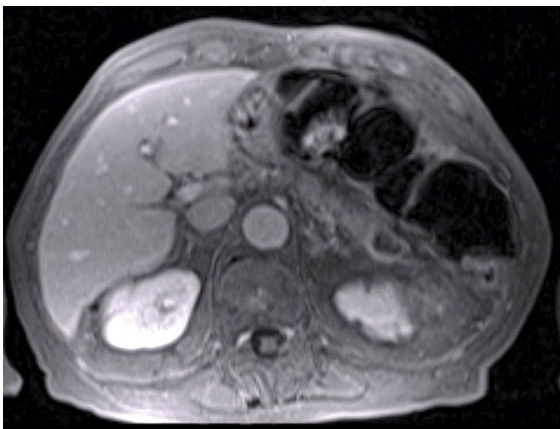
MRI after gadolinium showing a ring-enhancing lesion in the tail of pancreas.
